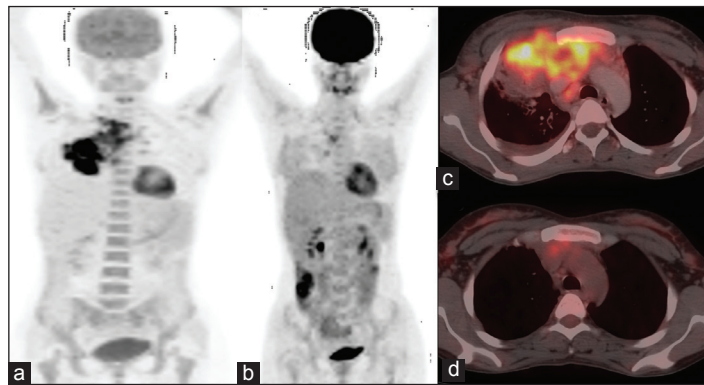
Maximum intensity projection image (a) of a patient with anaplastic large cell lymphoma shows intensely fluoro-deoxy-glucose (FDG) avid disease in the mediastinum in staging positron emission tomography/computed tomography (PET/CT). PET/CT done after eight cycles of chemotherapy show (b) mildly FDG avid disease in mediastinum. Transaxial images of pre and post therapy scans (c and d respectively) show mild FDG uptake in the mass that is above mediastinal blood pool activity. Also the sum product diameter of the mass has decreased by more than 50%. According to International Harmonization Project criteria decrease of 50% or more of lymph nodes involved along with persistent FDG uptake above mediastinal blood pool is classified as a partial response. Accordingly the patient was classified as partial responder and patient presented with progressive disease 4 months after the post therapy scan and was put on salvage chemotherapy
